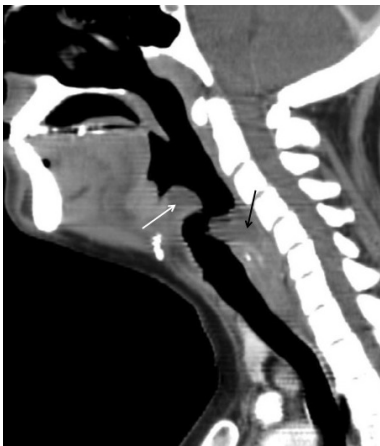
Epiglottitis. Sagittal reformatted contrast enhanced CT demonstrates the edematous epiglottis (white arrow) and prevertebral (apagar) soft tissue swelling between cervical spine and upper airway due to pharyngeal mucosal space collection (black arrow). Note that a retropharyngeal space collection should extend inferiorly to the mediastinum.
